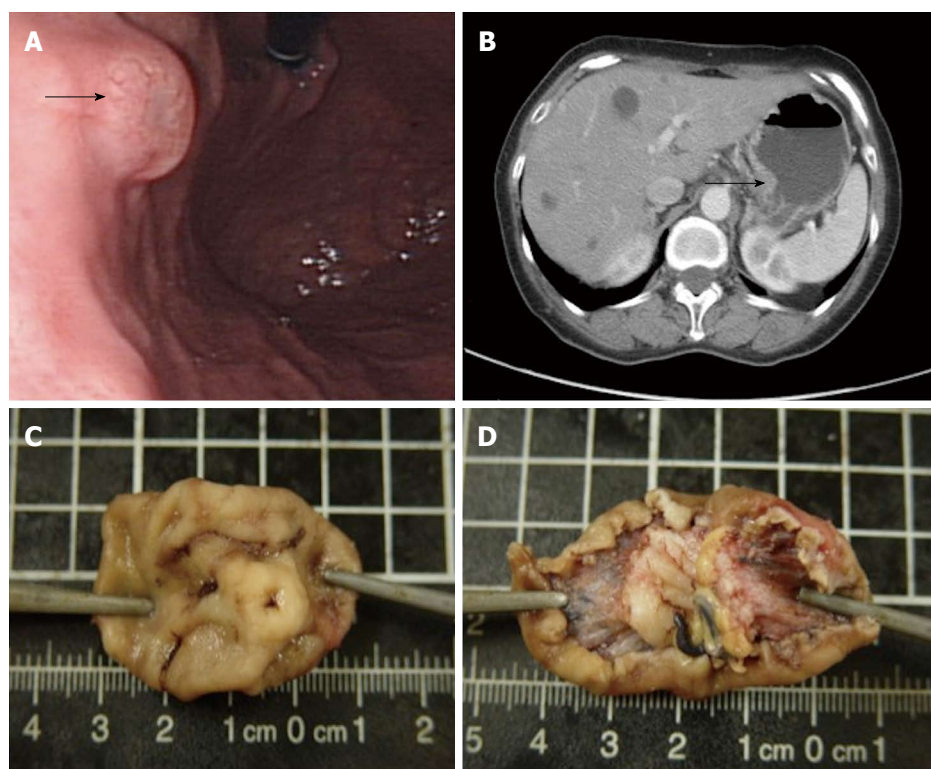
Endoscopy reveals a polypoid mass (arrow) (A); an isolated mural lesion was seen in computed tomography scan (arrow) (B); and grossly, a polypoid submucosal tumor is noted (C, D).
